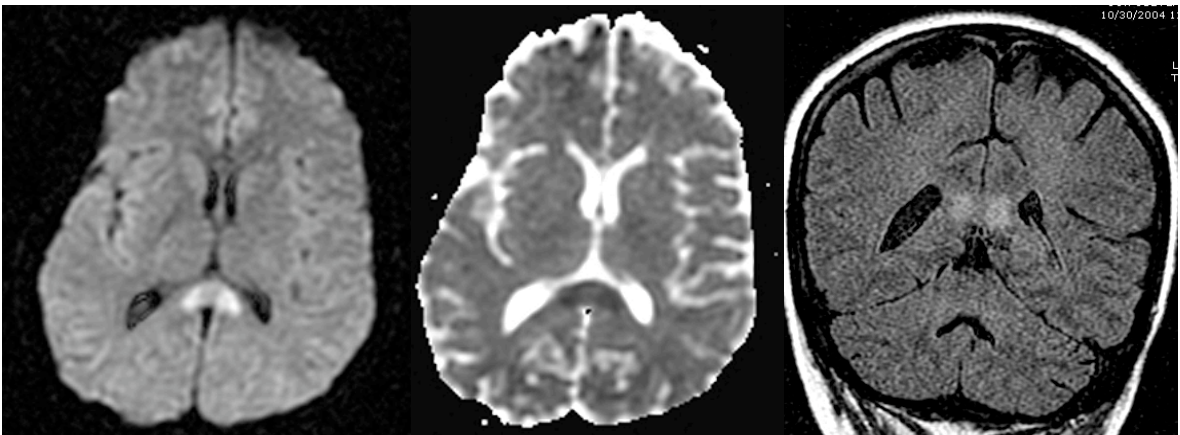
42 year-old patient on lamictal, topamax, and tripeptal. Images (left to right: axial DWI, ADC, coronal FLAIR) demonstrate increased DWI signal with corresponding low ADC in the splenium of the corpus callosum.
